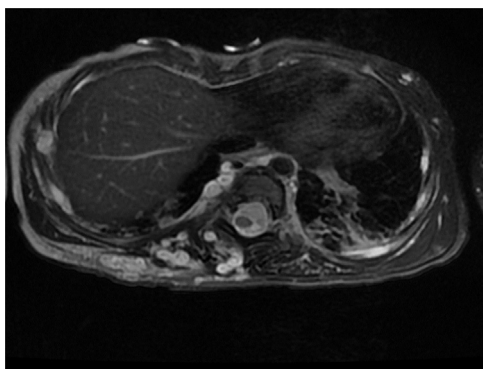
Axial MR imaging through the abdomen demonstrates high T2 signal abnormality along bilateral thoracic paravertebral regions along the sympathetic chain, which extend bilaterally along the ribs, right greater than left and into the right paravertebral soft tissues. MR, magnetic resonance.
